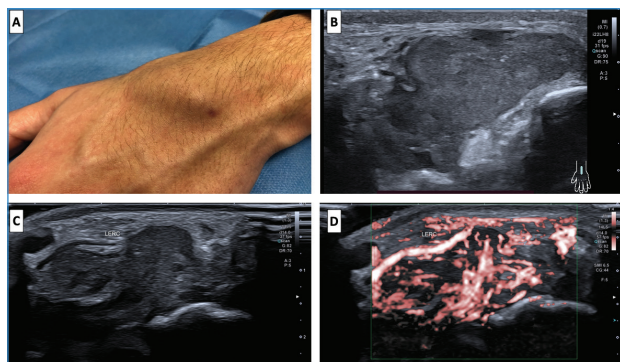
A – Tumefação da face dorsal do punho esquerdo; B a D – Ecografia do punho com hiperprofia sinovial intercárpica e sinal de doppler marcados
